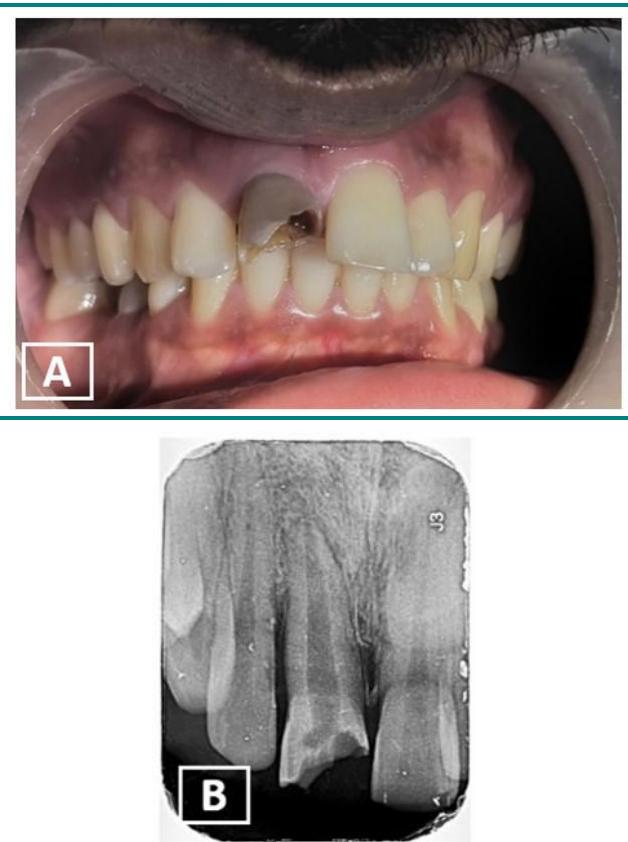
A. Preoperative clinical photograph, and B. Preoperative intraoperative periapical radiograph of tooth 11.
